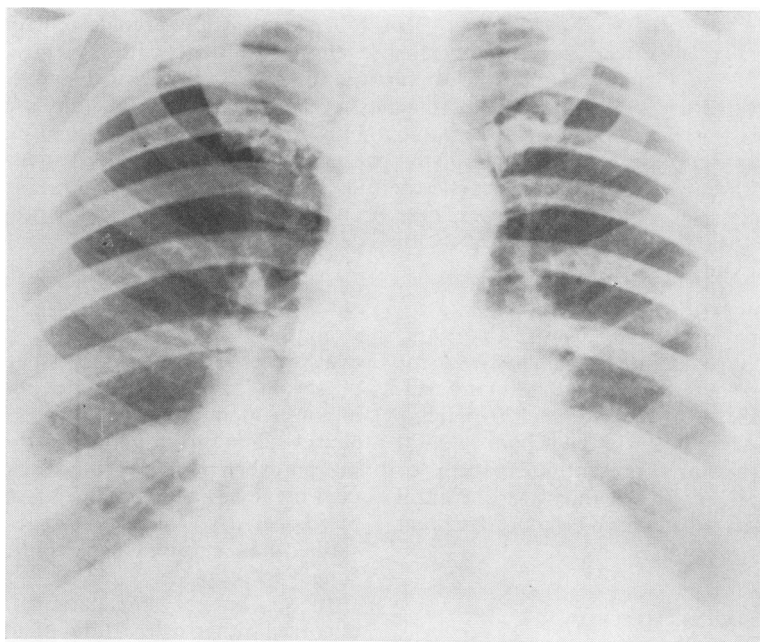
A postero-anterior chest radiograph showing right hilar adenopathy and pulmonary infiltration.
